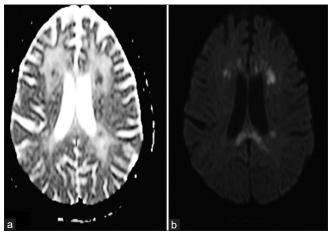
Imaging MRI of the case report (a) Apparent diffusion coefficient (ADC) showing areas of reduced signal intensity in bilateral periventricular white matter; (b) - Diffusion weighted image (DWI) showing high signal intensity areas in bilateral periventricular white matter and splenium of corpus callosum. Source: Author's own work
